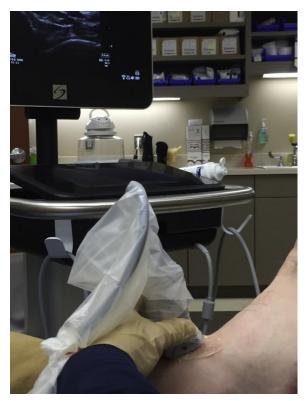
Position of ultrasound transducer and machine for ankle joint injection in plane with joint. Left, proximal; right, distal.
